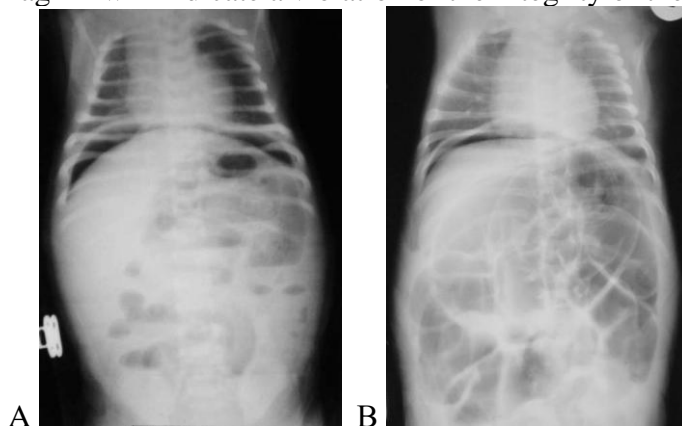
Survey X-ray in a vertical position. A - free gas under the right and left domes of the diaphragm; B - free gas under the right dome of the diaphragm.
